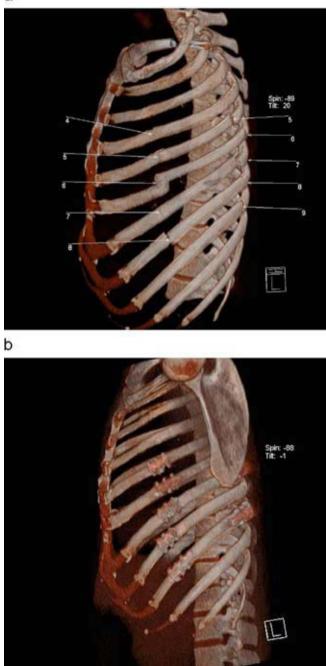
Unstable chest: a) chest CT-preoperative study; b) chest CT-postoperative study.
